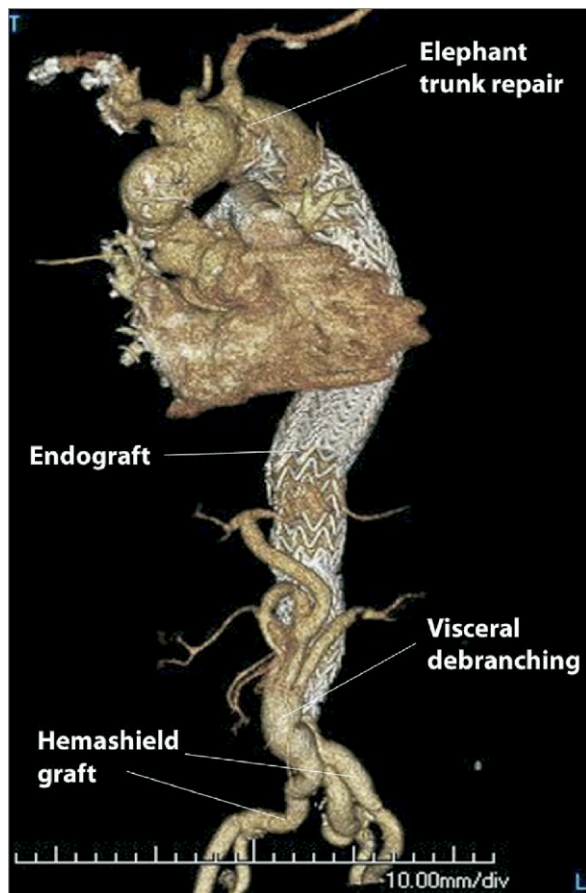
A computed tomography three-dimensional reconstruction after (1) repair of the aortic arch with elephant trunk procedure; (2) resection of the infrarenal abdominal aortic aneurysm and bilateral common iliac arteries and reconstruction with bifurcated Hemashield graft (Boston Scientific, Natick, Mass) to the iliac bifurcations; and (3) endograft placement in the true lumen of the descending thoracic aorta. Note that the celiac, superior mesenteric artery, and left renal arteries now arise from the false lumen after luminal shift secondary to endograft deployment. The diameter of the descending thoracic aorta increased in size from 4.6 to 6.1 cm in a 6-month period.
